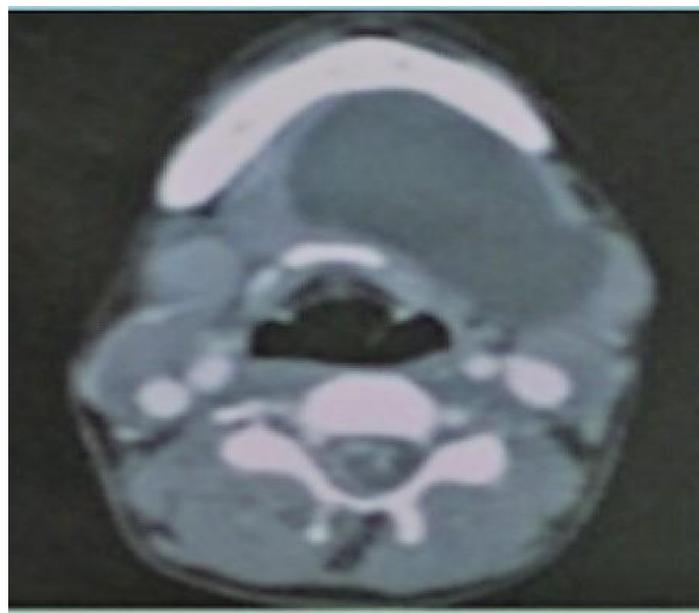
A. CT Scan showing Ranula
